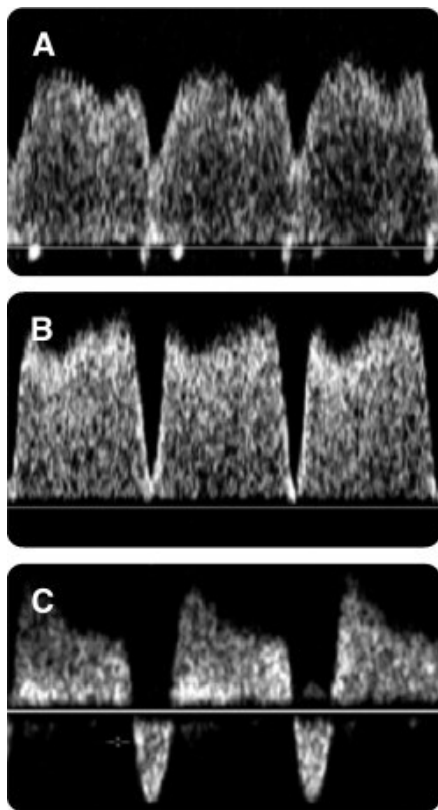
Color Doppler examination of the ductus venosus with normal flow velocity waveforms (A). Abnormal waveform with reversal of flow during atrial contraction and markedly increased pulsatility in a FGR fetus (B, C).
